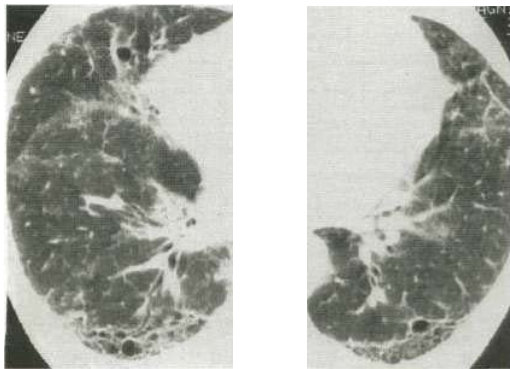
CT scan showing cryptogenic fibrosing alveolitis.
